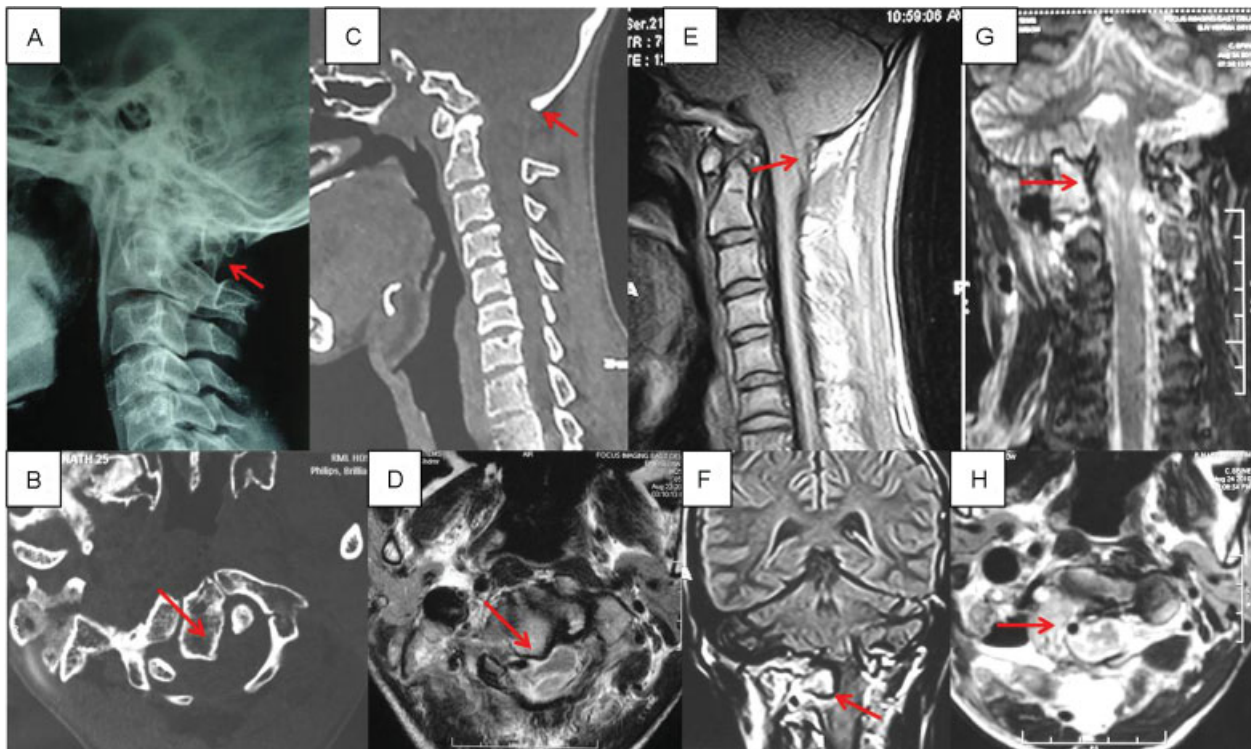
Preoperative. (A) Plain radiograph of the cervical spine in lateral view shows a small bony fragment projecting between occipitalized posterior arch of C1 and C2 vertebra (arrow). (B) Axial computed tomography (CT) image of CVJ shows fracture of anterior arch of C1 vertebra along right lateral aspect with posteromedial dislocation and rotational abnormality of fractured fragment (arrow). (C) Sagittal reconstructed CT image of CVJ on bone window setting shows occipitalization of posterior arch of C1 (arrow). (D) Axial T2-weighted magnetic resonance (MR) image of CVJ at C1 level shows the fractured bony fragment (arrow) compressing the thecal sac along the right anterolateral aspect causing rotational compression and left lateral deviation of cervicomedullary junction (CMJ). (E) Midline sagittal T1-weighted MR image of CVJ shows tonsillar herniation (arrow) below foramen magnum with compression of CMJ. (F) Coronal T1-weighted MR image at the level of C1 lateral mass reveals medial displacement of right C1 lateral mass (arrow) compressing the CMJ. (G) Postoperative coronal and (H) axial T2-weighted MR images of CVJ showing surgical removal of right lateral mass of C1 (arrow) with decompressed CMJ.
